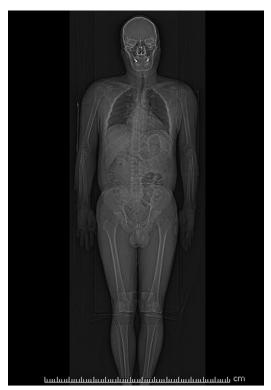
A scanned projection radiograph of the entire trunk of the body obtained in computed tomography. (Courtesy Colin Bray, Baylor College of Medicine.)
